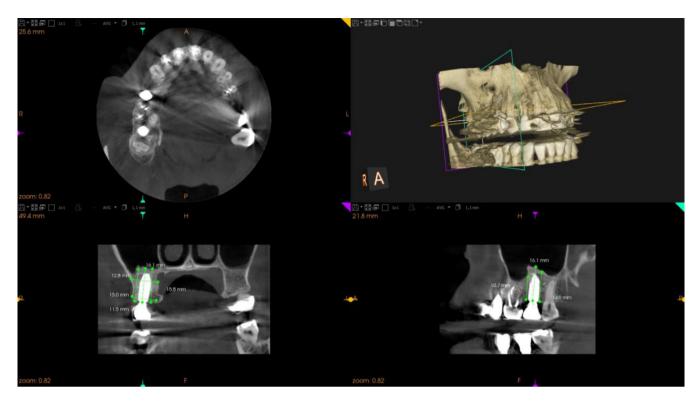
Linear measurements with 3shape software at 1 year follow up CBCT. Bone height was determined calculating the average of three different measurements. The buccolingual diameter was measured at a distance of 10 mm from the margin of the bone crest.
